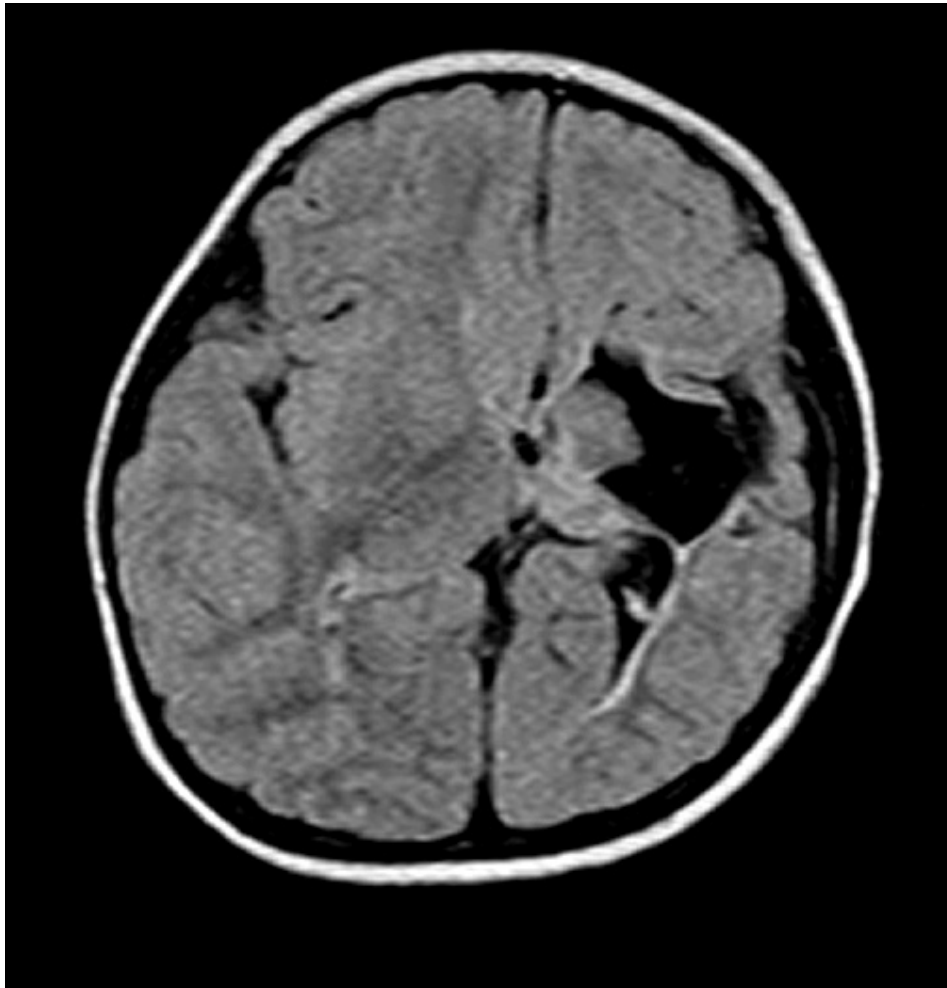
T2W Axial flair MRI images of a patient with Rasmussen's encephalitis taken six months apart (A) and (B) showing progression of disease
